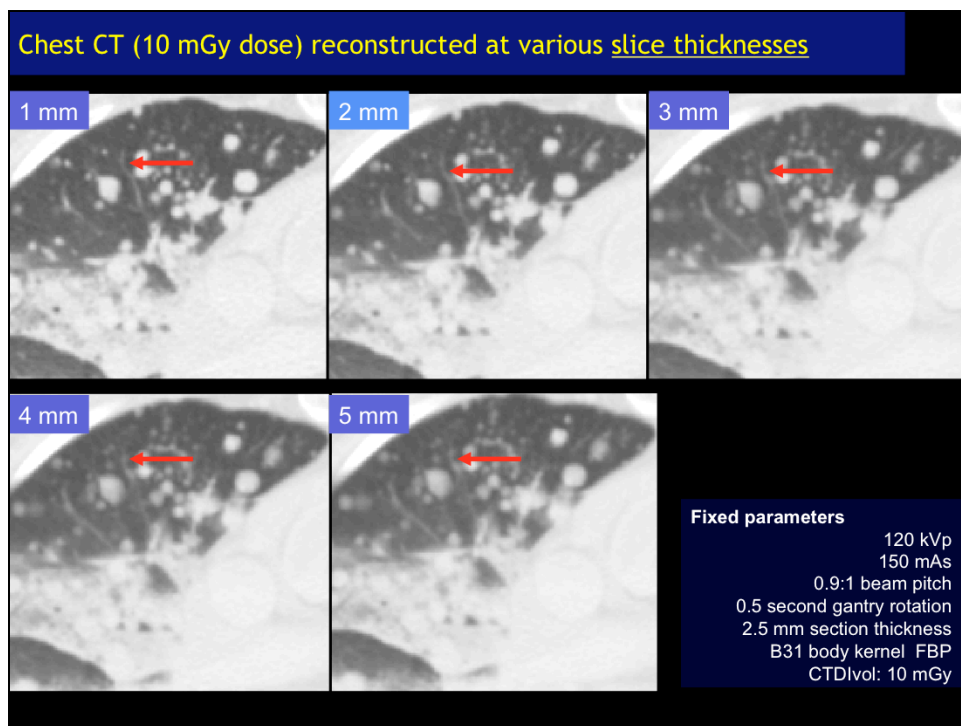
Transverse chest CT images acquired at 150 mAs (CTDIvol 10 mGy) and reconstructed at di
